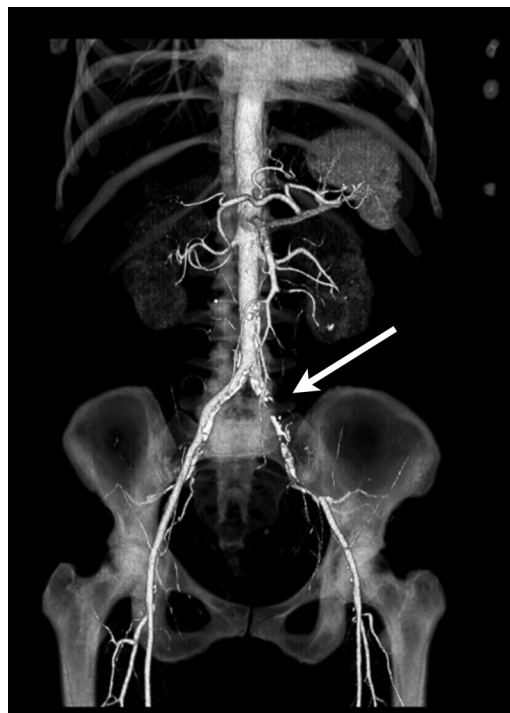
Digital reconstruction of computed tomography angiography of abdomen-pelvis showing a left common iliac and left external iliac thrombosis (arrow).
